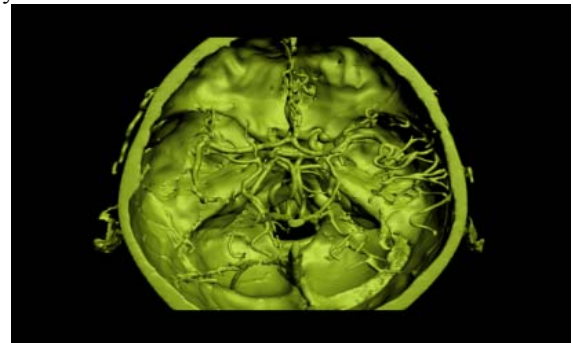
CT angiography original figure
